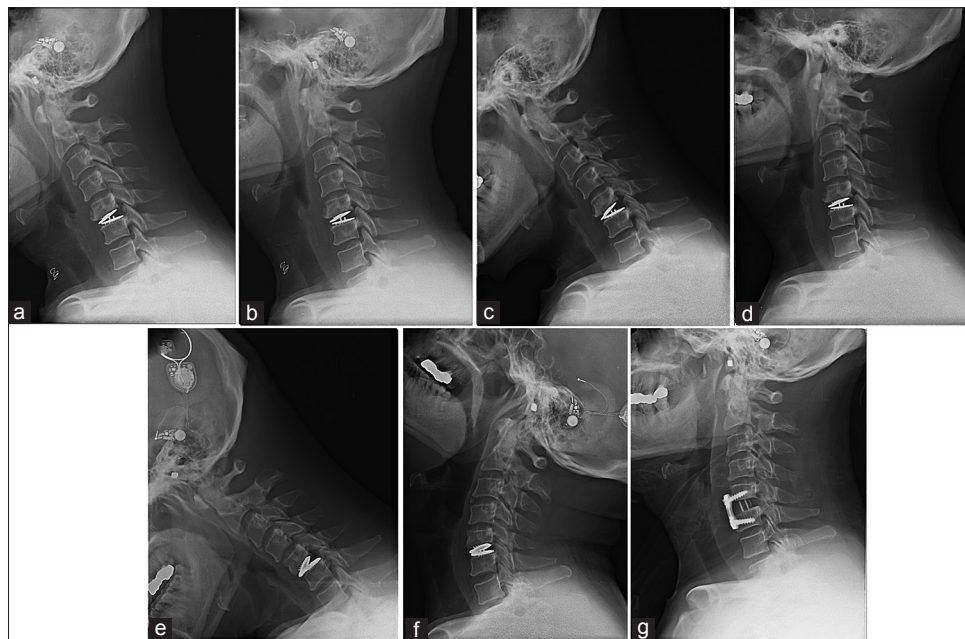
(a) Postoperative – 1 week, (b) Postoperative – 1 week, (c) Postoperative – 2 months, (d) Postoperative – 2 months, (e) Postoperative – 14 months, (f) Postoperative - 14 months showed an aggravation of cervical instability at C5-6. Cervical instability at C5-6, the ADR site, aggravated in the temporal order of (a-f). (g) Radiograph obtained after a revision operation, in which the ADR implant was removed and ACDF was performed.
